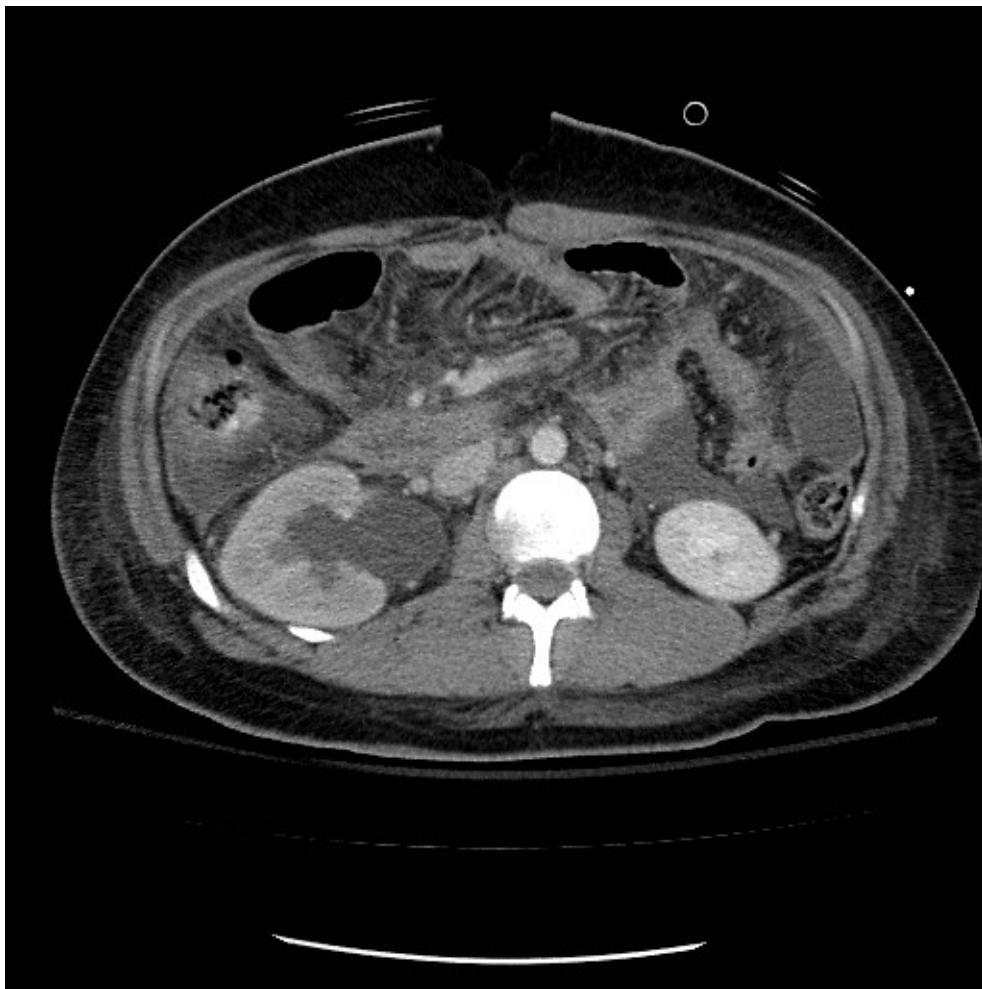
Computed tomography scans demonstrating an ipsilateral delayed pyelogram and hydronephrosis in a patient with delayed recognition of a penetrating mid-ureteral injury
